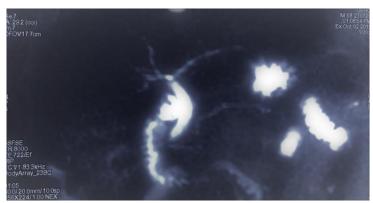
CP-MRI showing multiple segmental short stenoses in the right and left bile ducts
